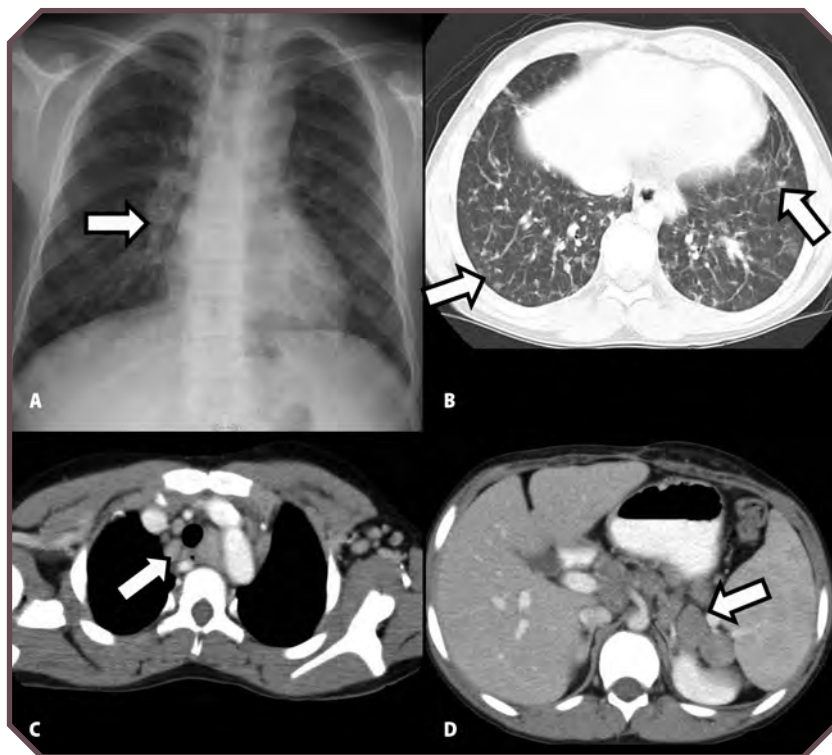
Sarcoidosis in a 6-year-old girl with chronic cough. A. Frontal chest radiograph demonstrates bilateral, coarse reticulonodular markings; right hilar adenopathy (arrow); and mediastinal widening, which suggests additional nodes. B. Axial chest computed tomographic (CT) lung window shows bilateral reticulonodular interstitial markings and demonstrates interstitial markings with multiple superimposed, ill-defined focal nodules (arrows). C. Axial contrast-enhanced CT image of the upper chest confirms mediastinal lymphadenopathy (arrow). D. Axial CT image of the abdomen shows extensive retroperitoneal nodes (arrow).
